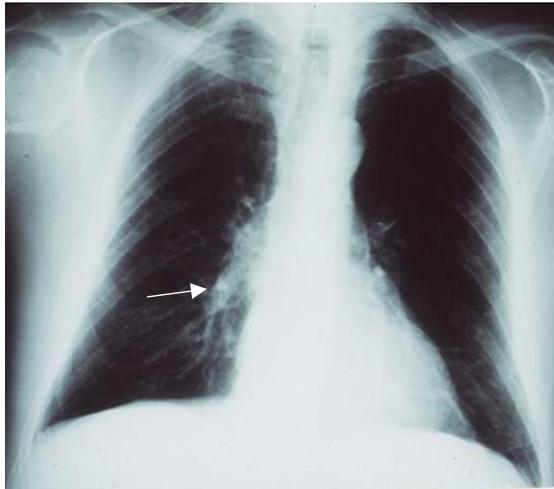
A right hilar mass (arrow) is noted on chest radiograph.
